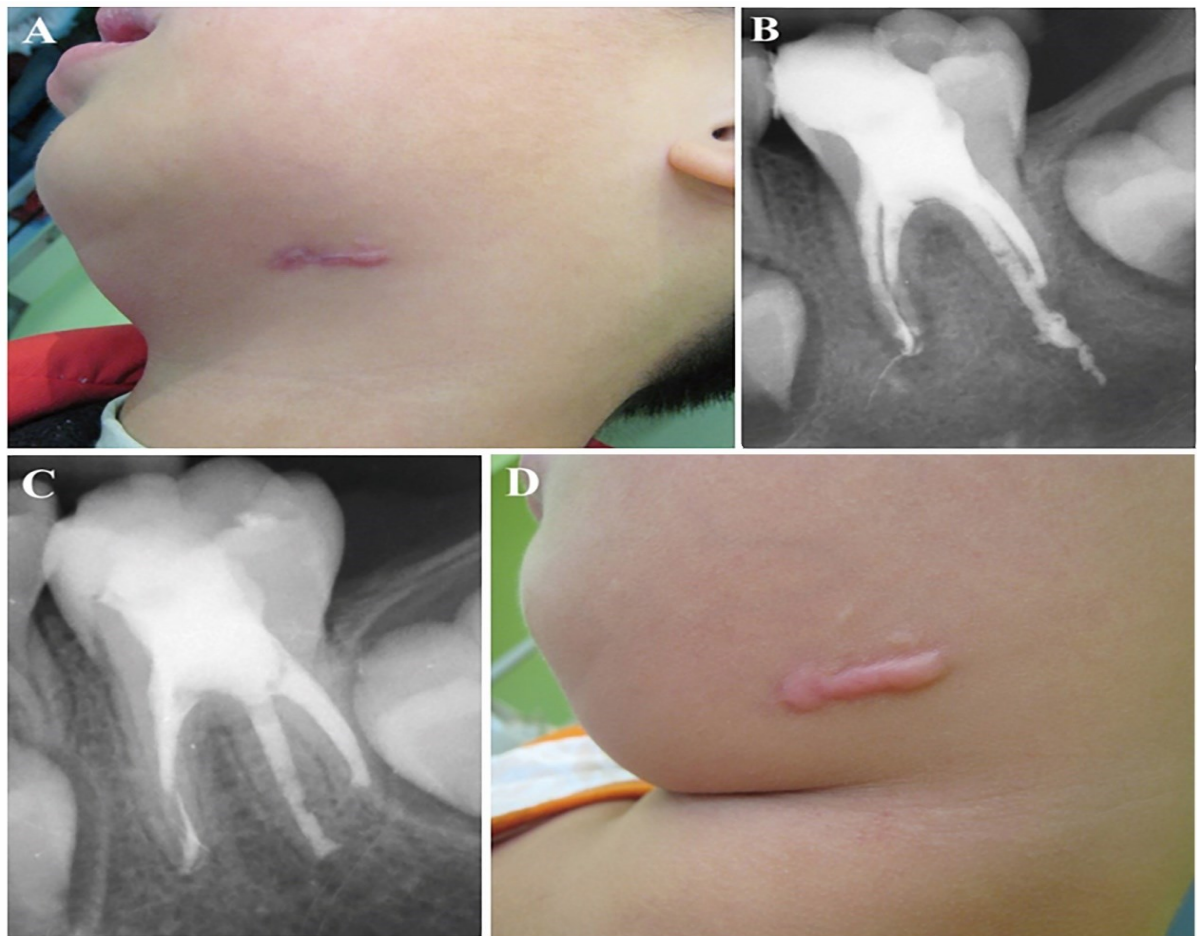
(A) After 2-week intracanal dressing with calcium hydroxide paste, healing of the cutaneous lesion had occurred. (B) Radiograph after applying a premixed calcium hydroxide paste with iodoform to the root canals. (C) Radiograph showing resolution of the periradicular radiolucency, formation of the calcified barrier at the mesial root apices and initiation of apexification. (D) Extraoral photograph after 7 months, showing hypertrophic scar formation.
